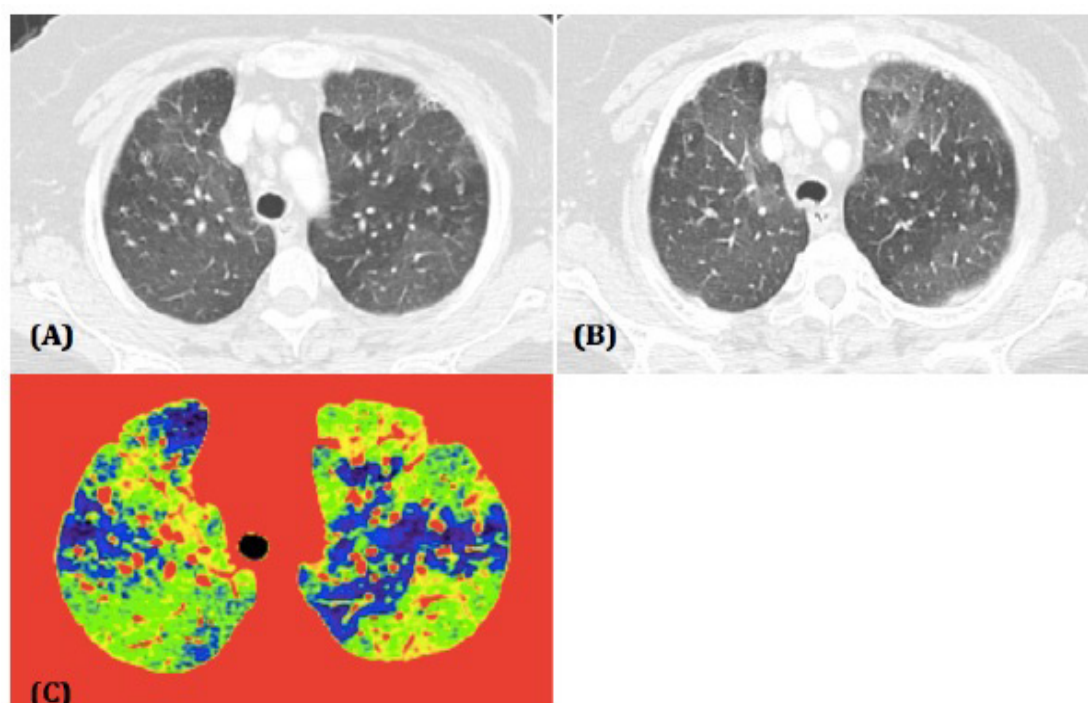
A 45-year-old male patient with constrictive bronchiolitis. (A) Axial inspiratory CT section through the upper lobes demonstrates mosaic attenuation pattern, the density differences in the lung parenchyma are subtle. (B) Expiratory CT image shows accentuation of the geographic low attenuation areas of air trapping, the adjacent areas of higher-attenuation lung represent the expected increase in attenuation at expiratory imaging, bowing of the posterior wall of the trachea (*arrow*) signifies good expiratory effort. (C) Corresponding combined narrow window color-coded inspiratory CT image clearly identifies the air trapping areas (*blue areas*).
